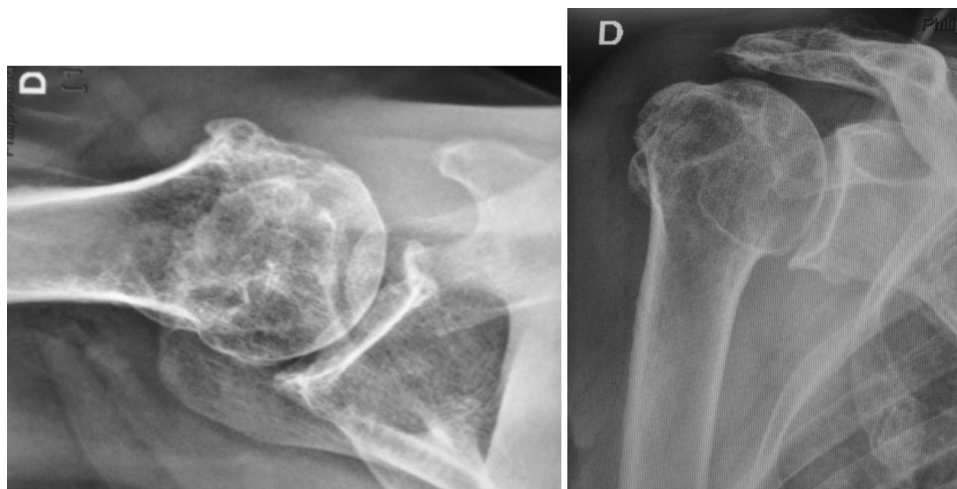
X-rays in anteroposterior and axillary incidence of a shoulder with rotator cuff arthropathy.
